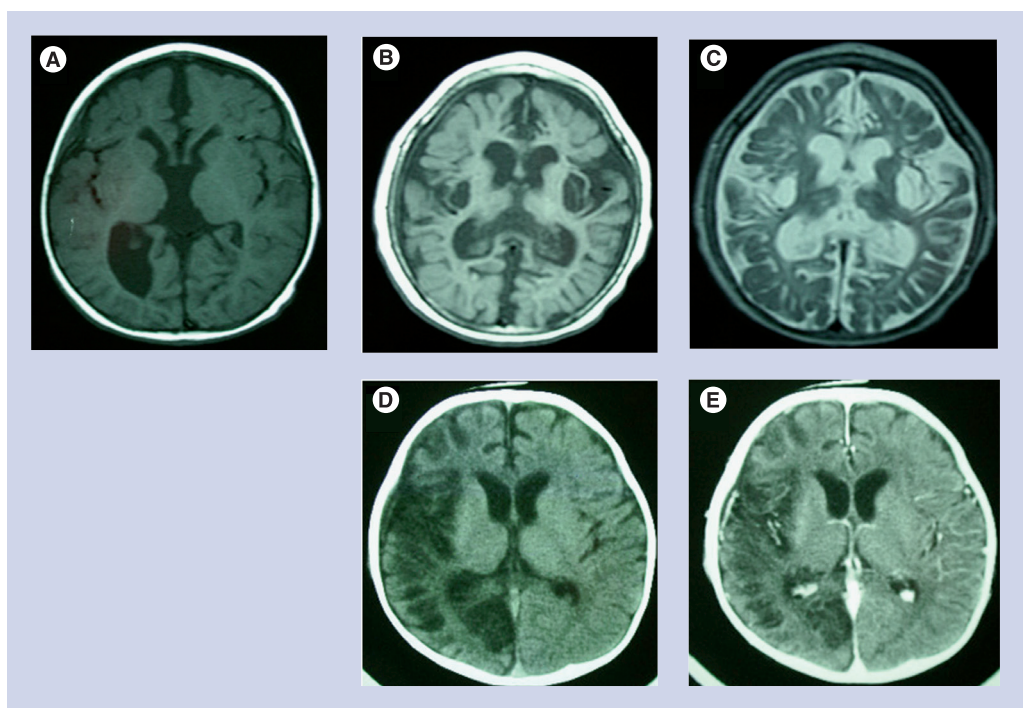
Cranial magnetic resonance images and computed tomography of each case. (A) A T1-weighted image (T1WI) of Case 1 revealed brain atrophy in the spread of the gyri and expansion of the posterior corner of the right cerebral ventricle. There is atrophy of the whole cerebrum with hypotrophy of the gray matter. (B) A low-intensity area on a T1WI and (C) a high-intensity area on a T2-weighted image (T2WI) in the bilateral basal nuclei were noted in Case 2. (D) Plane computed tomography of Case 3 revealed right cerebral hemiatrophy, especially in the low-intensity area supported by the right middle and posterior cerebral arteries; (E) on enhanced computed tomography, the spherical corpus callosum did not appear to be injured.
